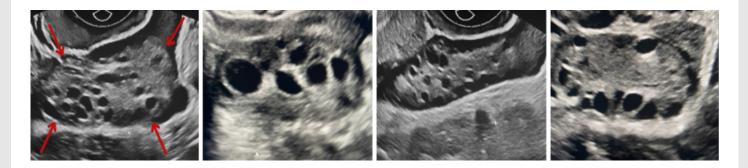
Ultrasound images of polycystic ovaries. Cysts appear as rounded black structures in the peripheral zone of the ovaries.
